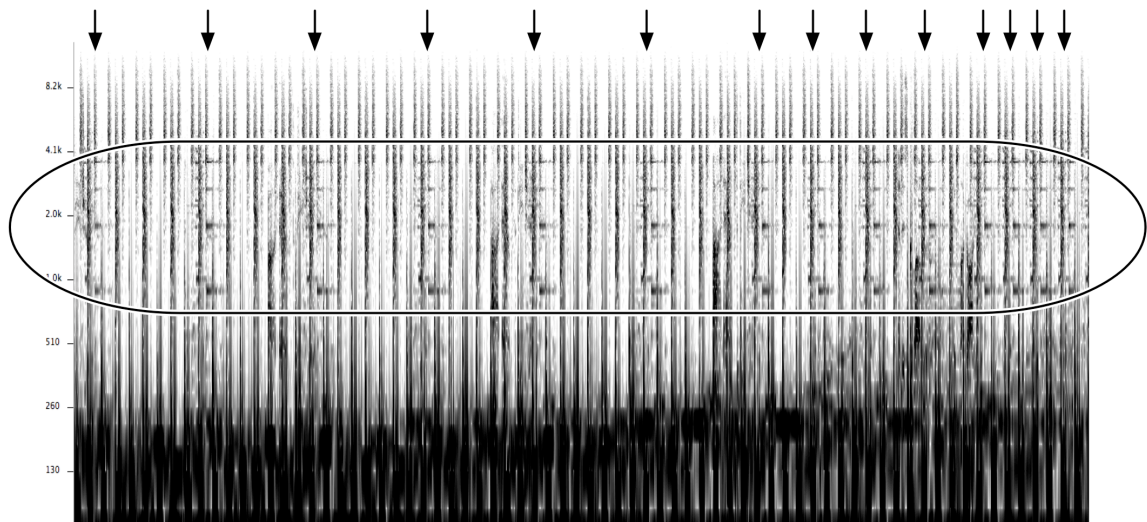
Sonogram of Romanthony’s *Floorpiece*, 0:01–0:35, with circle and arrows indicating repeated events.
